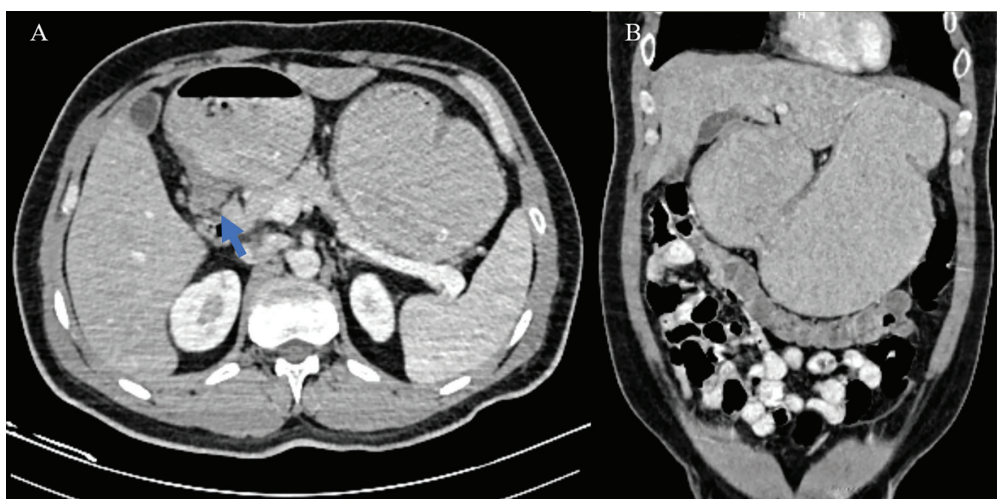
A. The abdominal CT scan shows a thickened distal gastric antrum and a narrowed pylorus (indicated by the blue arrow). B. The coronal view of the abdominal CT scan shows marked gastric distension
